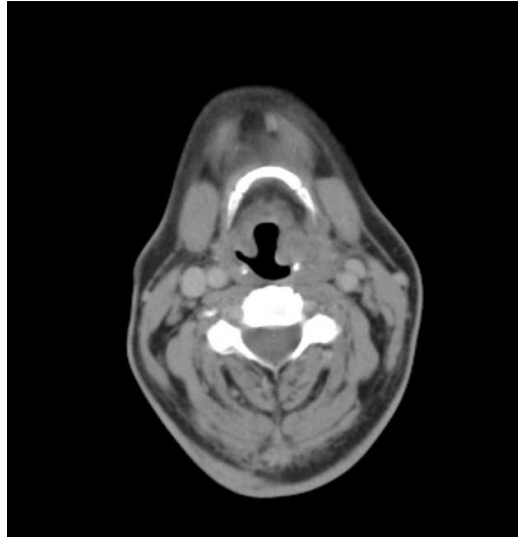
CT Scan neck shows soft tissue lesion circumferentially involving supra glottic region. Effacement of bilateral pyriform fossa with predominant involvement on left side noticed. Extralaryngeal spread to adjacent paralaryngeal space seen on left side.
